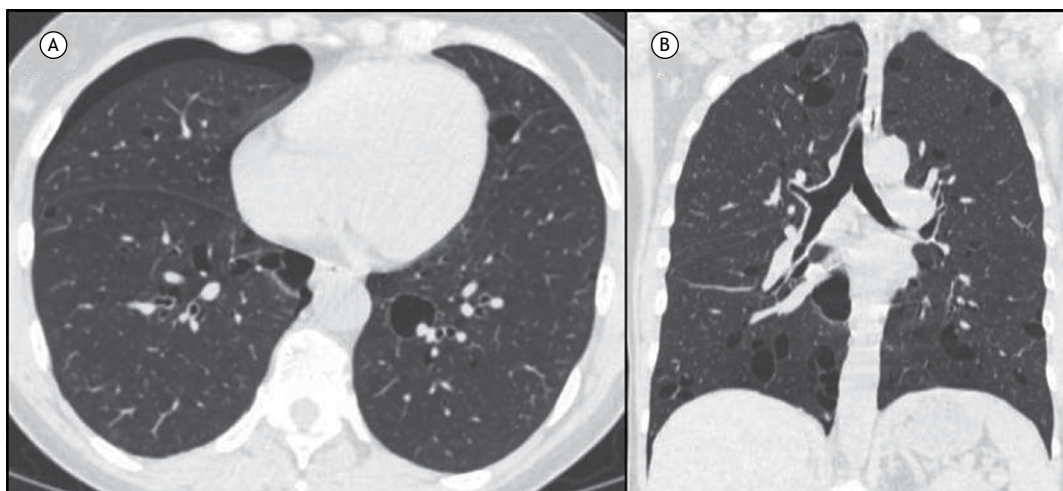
In A, axial reconstruction of a CT scan demonstrating thin-walled lung cysts and a right pneumothorax. In B, coronal reconstruction of a CT scan showing the distribution of the cysts in the lower lobes, a predominantly medial distribution. The patient in question was a 49-year-old female, had sudden dyspnea, and was diagnosed with Birt-Hogg-Dubé syndrome. The diagnosis was confirmed by the presence of characteristic lung cysts and a spontaneous pneumothorax and by a history of a first-degree relative with the disease.
